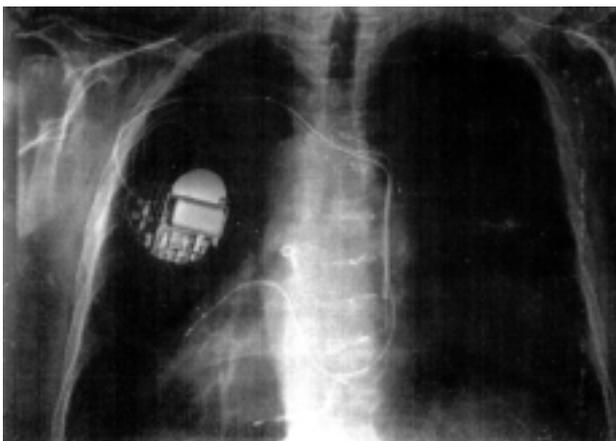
Pre-discharge chest X-ray showing dextrocardia and the final position of all the leads.
